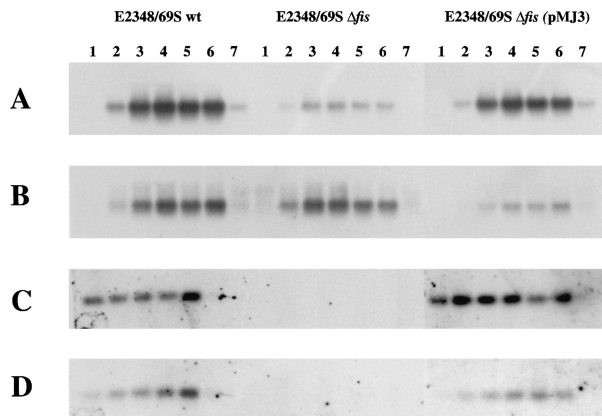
Multiplex primer extension analysis to monitor expression of several genes simultaneously in the same RNA sample. RNA was extracted from E2348/69S, E2348/69S Δ *fis* and E2348/69S Δ *fis* (pMJ3) grown in DMEM + 0.1% glucose and sampled at 0.5 h (lane 1), 1.5 h (lane 2), 2.5 h (lane 3), 3.5 h (lane 4), 4.5 h (lane 5), 5.5 h (lane 6) and 6.5 h (lane 7). Unlabelled primers were designed to anneal 400–500 bp downstream of the 5' end of the (A) *espA*, (B) *tir*, (C) *ler* and (D) *sepL* transcripts and cDNA synthesized. After degrading the RNA, the cDNA products were electrophoresed and Southern blotted. Fluorescein-dUTP-labelled probes directed towards each cDNA product were hybridized individually with the blot and the signal recorded on X-ray film. Probes were stripped from the blot before hybridizing with the next probe. Essentially identical results were obtained from several independently performed experiments.
